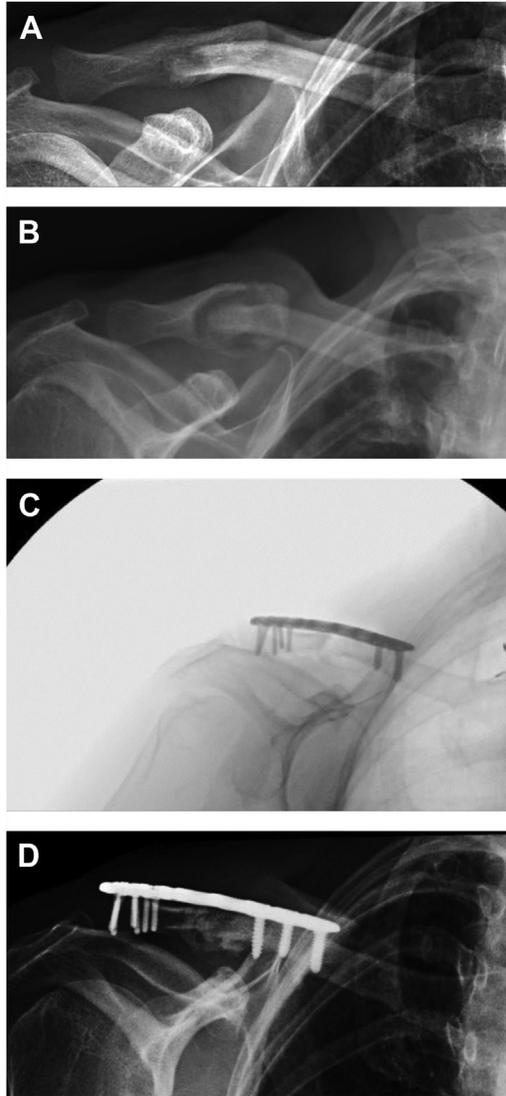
Caption: Case of a 64-year-old right-hand-dominant woman, (A) initially sustained a minimally displaced right lateral clavicle fracture after falling onto the pavement; (B) 1 year after her injury, radiographs revealed hypertrophic nonunion of her lateral clavicle; (C) She was then treated with a precontoured locking plate (Acumed, Hillsboro, OR, USA) to obtain fixation and (D) went on to achieve healing of the distal clavicle nonunion at 5 months follow-up.
